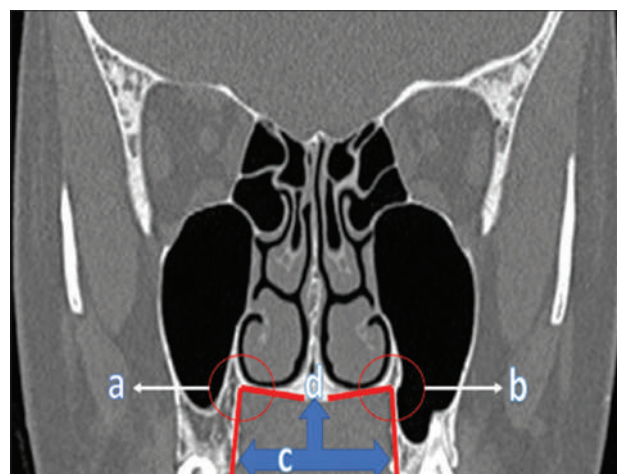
Coronal CT image showing right MPA (a), left MPA (b), IAD (c) and MSD (d) measurements, CT: Computed tomography, MPA: Maxillopalatal angle, IAD: Interalveolar distance, MSD: Maxillary spin distance
